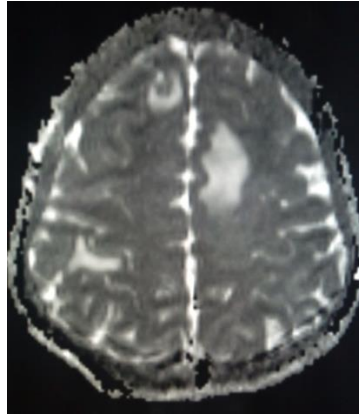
A&B DWI and ADC images showing infarct in left parietal lobe.
